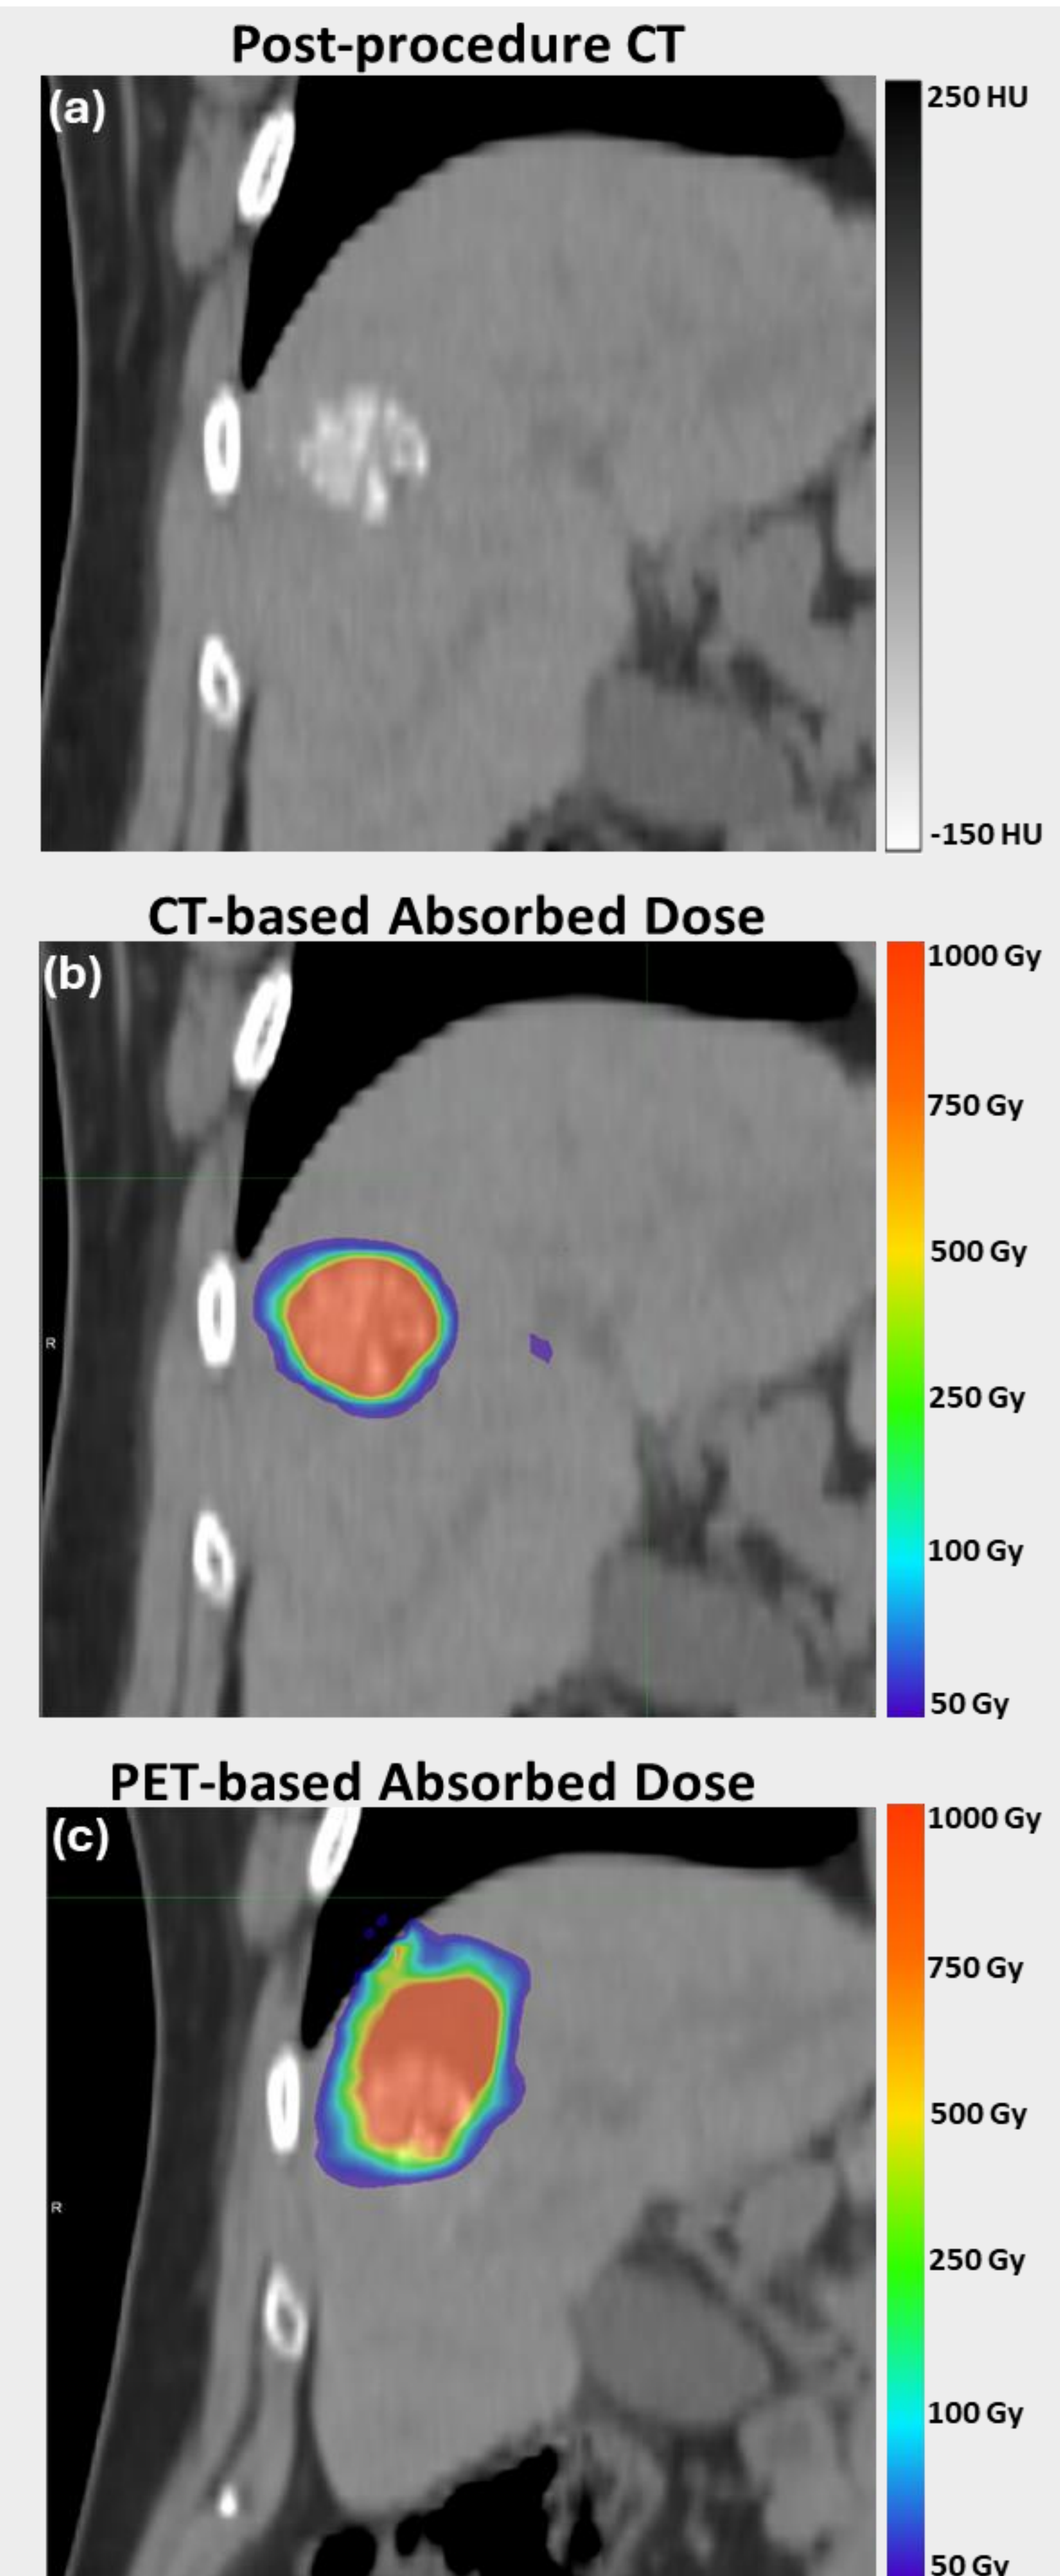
(a) Post-procedure CT showing Eye90 microsphere uptake in the tumour. (b) The post-procedure CT fused with the CT-based absorbed dose distribution. (c) The post-procedure CT fused with the PET-based absorbed dose distribution.
